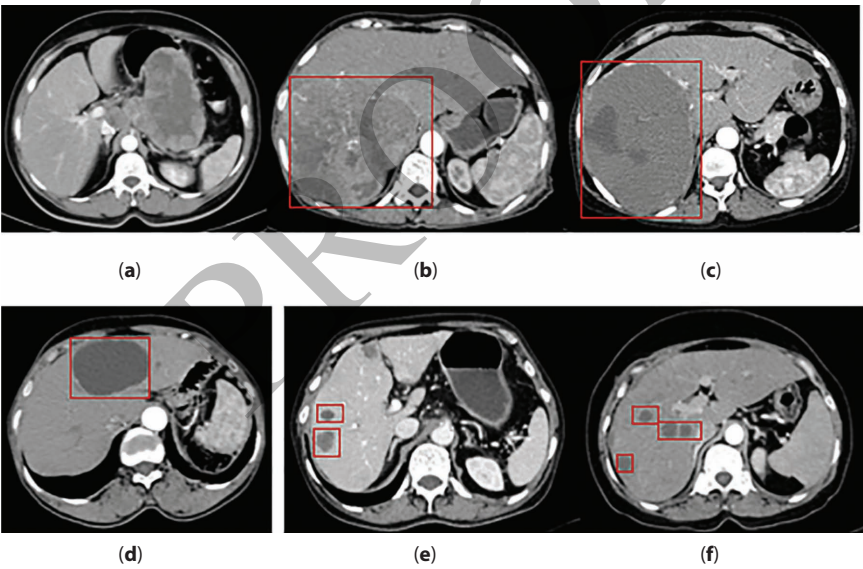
HA Phase Liver CT images: (a) normal liver; (b) HCC; (c) hemangioma; (d) cyst; (e) metastasis; (f) abscess.
